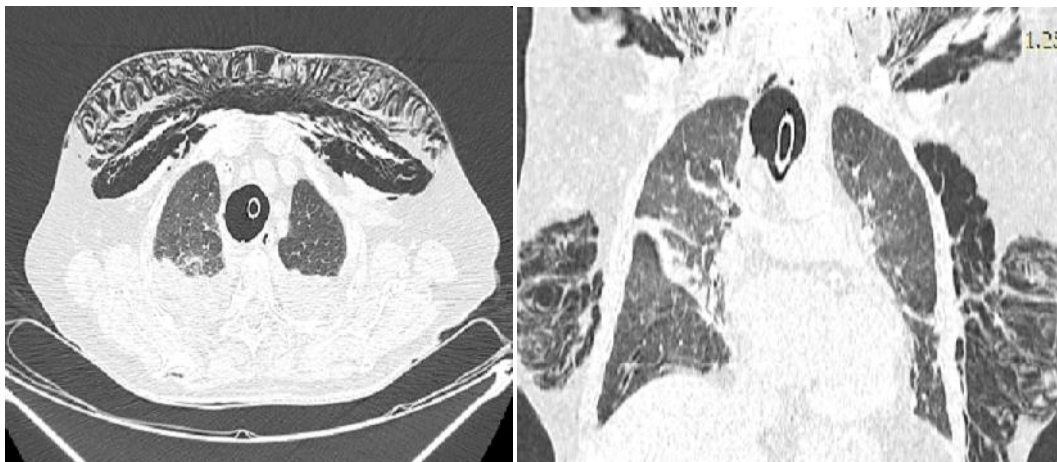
Axial and coronal computed tomography showing tracheal discontinuity associated with adjacent emphysema
